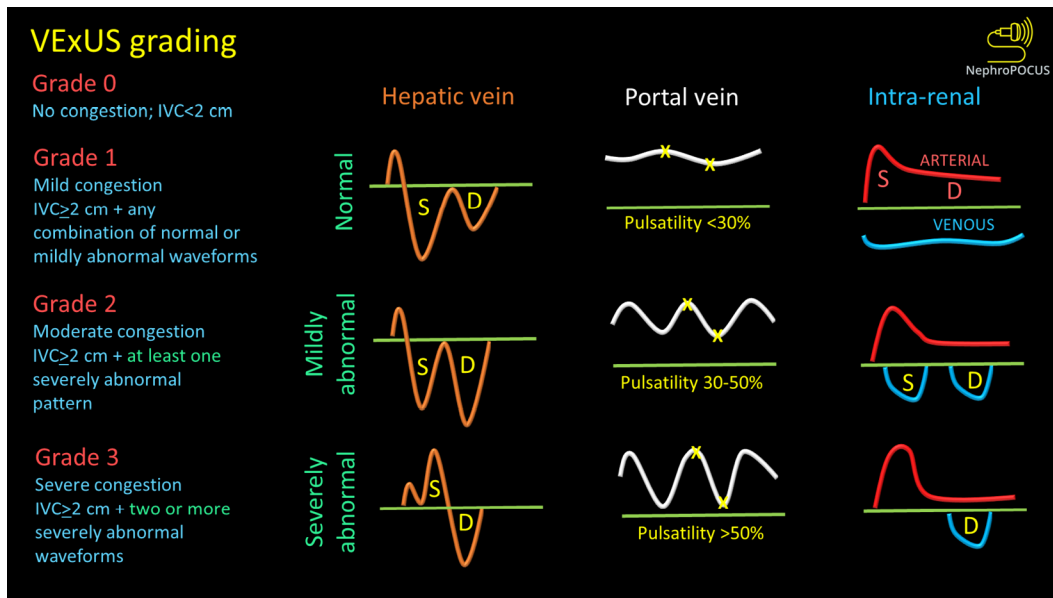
VexUS (Venous Excess Doppler UltraSound) grading system: When the diameter of inferior vena cava is > 2 cm, three grades of congestion are defined based on the severity of abnormalities on hepatic, portal, and renal parenchymal venous Doppler. Hepatic vein Doppler is considered mildly abnormal when the systolic (S) wave is smaller than the diastolic (D) wave, but still below the baseline; it is considered severely abnormal when the S-wave is reversed. Portal vein Doppler is considered mildly abnormal when the pulsatility is 30% to 50%, and severely abnormal when it is ≥ 50%. Asterisks represent points of pulsatility measurement. Renal parenchymal vein Doppler is mildly abnormal when it is pulsatile with distinct S and D components, and severely abnormal when it is monophasic with D-only pattern. Figure adapted from NephroPOCUS.com with permission (corresponding author's educational website)-<https://nephropocus.com/2021/10/05/vexus-flash-cards/>.
